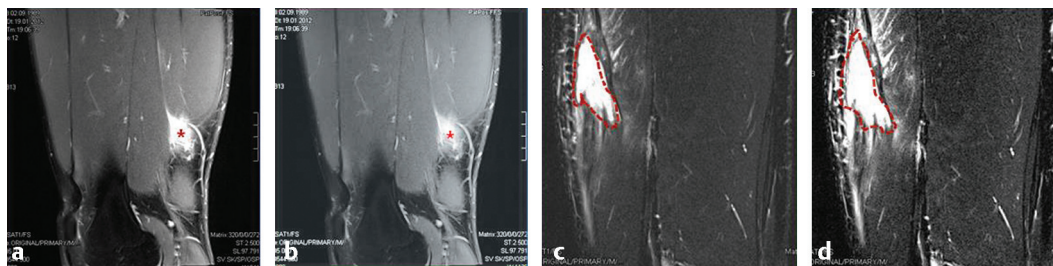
The sagittal magnetic resonance imaging sections demonstrate that contrast and brightness (which can be adjusted by the examiner on the radiological monitors) can sometimes play a crucial role in the interpretation of muscle injuries. In (a), for example, a high degree of brightness and a small amount of contrast can mimic a large muscle tear within the bright signal (*), leading to a potential misdiagnosis. (b) After adjusting the contrast and brightness, the actual defect in the muscle (with an adjacent edema) appears much smaller (*). (c, d) However, it is important to be aware that brightness and contrast do not influence the assessment of all structural muscle injuries. In the example of (c) and (d), the brightness and contrast do not significantly influence the imaging in terms of the actual size of the tear. The size of the tissue defect (surrounded with –) remains the same.
